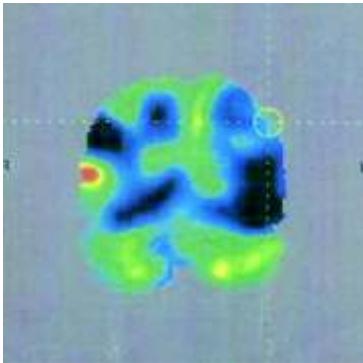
PET-CT scan before Autologous BMMNCs transplantation showing gliotic areas in black with areas of reduced metabolism in blue seen in bilateral parieto-occipital & right anterior inferior temporal region
